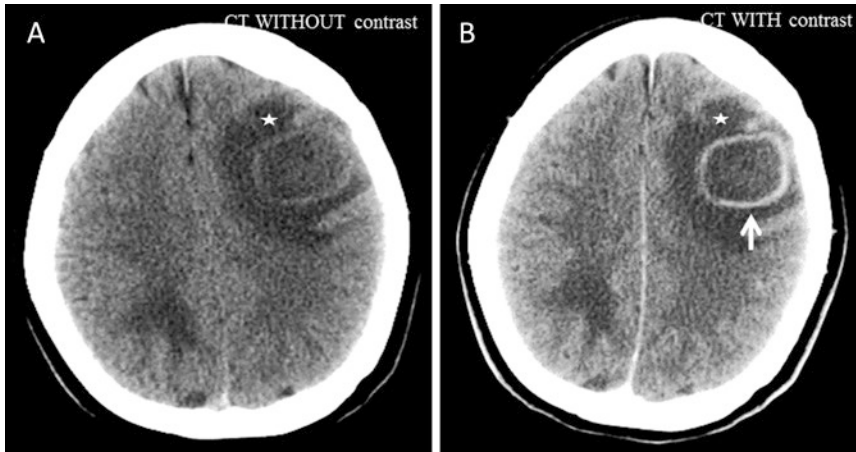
Axial plane CT without contrast (a) and postintravenous contrast injection (b) show a rounded lesion in the left frontal lobe with an enhancing-hyperdense ring
